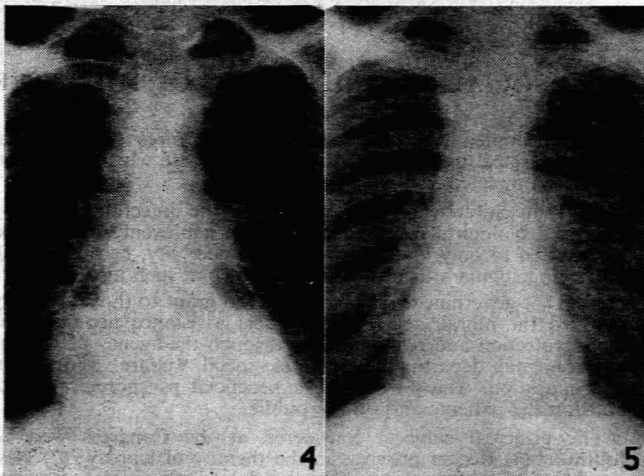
Case 2. X-ray after aspiration.
